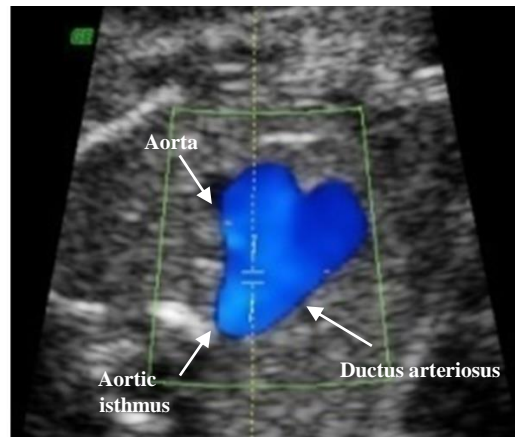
Insonation and flow velocity wave of aortic isthmus in the three vessel-trachea view. Observe the sample volume of the Doppler located just before the convergence between the aortic isthmus and ductus arteriosus
